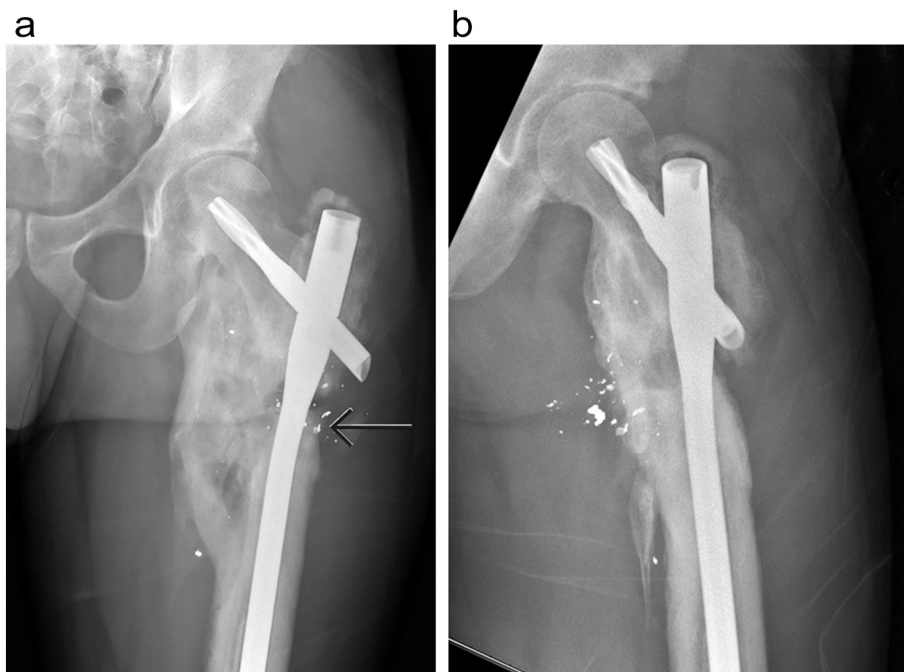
A and B: Radiographs AP and lateral of the left femur demonstrates radiographic union.
